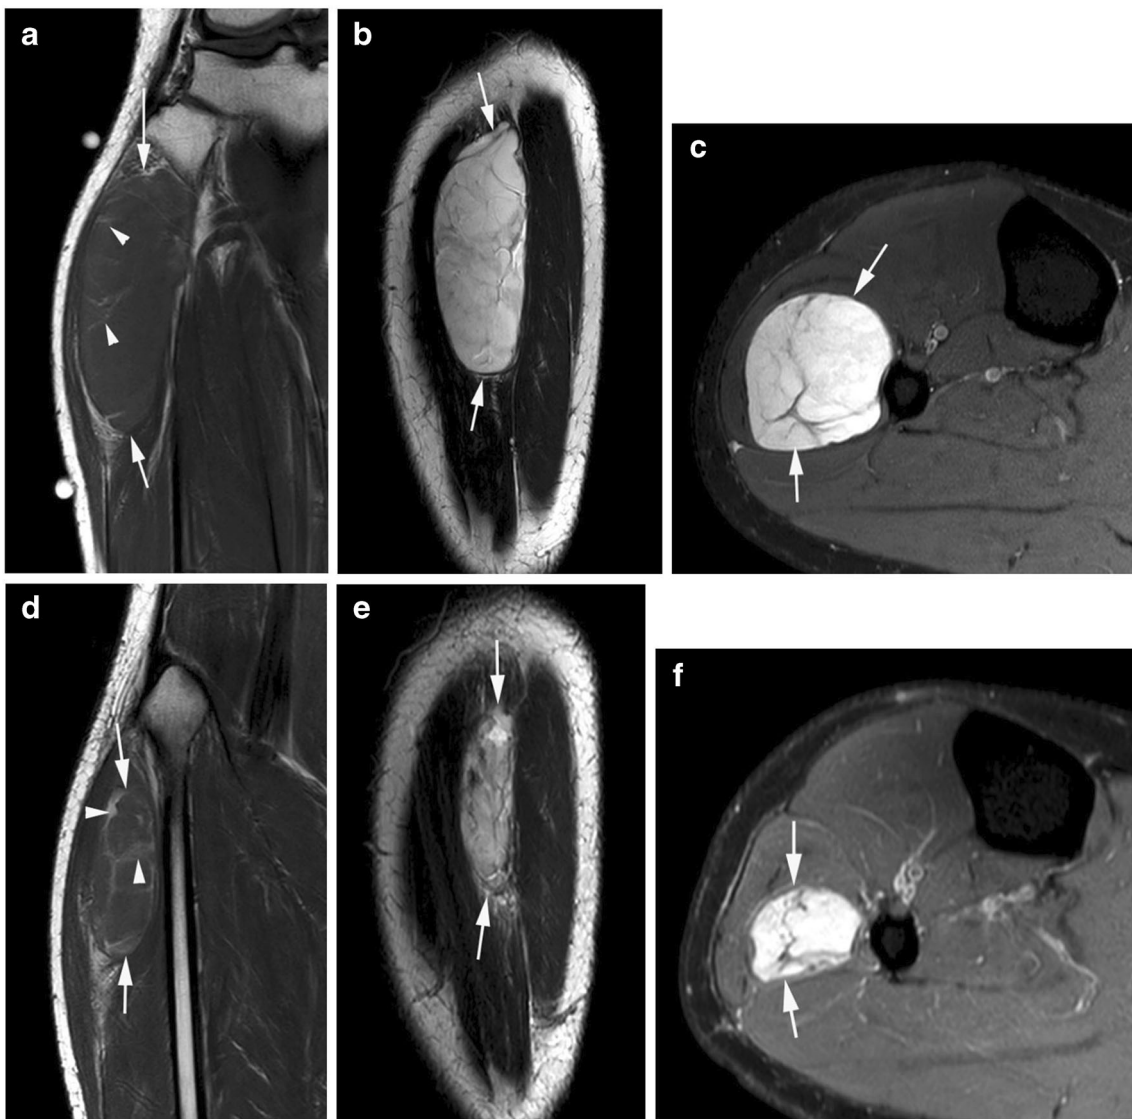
A 43-year-old male presenting with a mass in the lateral aspect of the right proximal calf. a Coronal T1W TSE, b sagittal T2W FSE, and c axial SPAIR MR images show a well-defined, elongated mass (arrows) which is isointense to muscle on T1W and hyperintense on T2 and STIR. The lesion contains thin septal fat on T1W (arrowheads-a) and has a thin hypointense capsule with hypointense internal septa on T2W and SPAIR.
